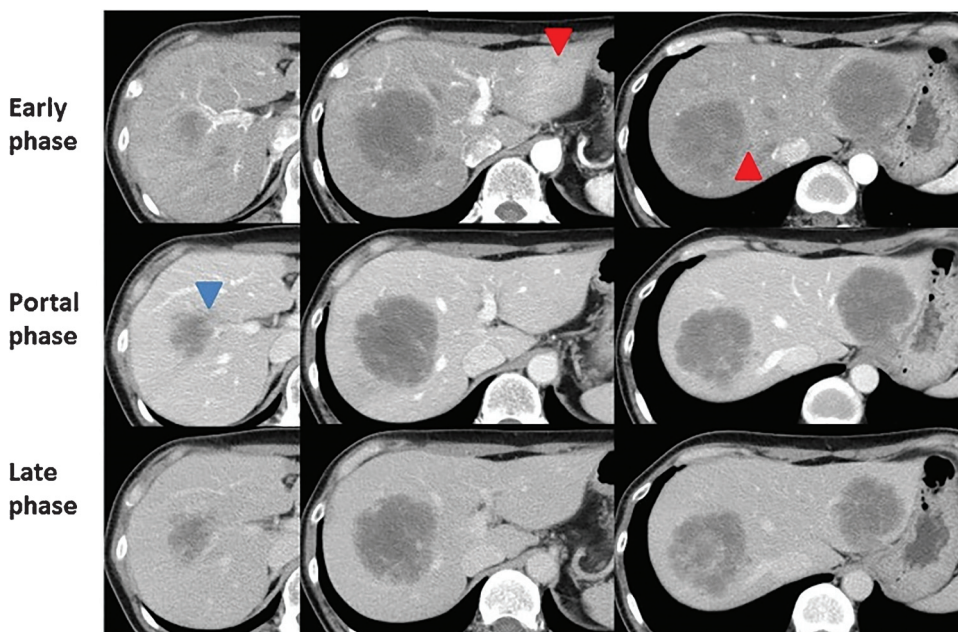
CT images at admission. Computed tomography (CT) showed two low-density masses of 68 mm in diameter in hepatic segments 2 and 3 and 72 mm in diameter in segment 8 as the main loci. These tumors were diagnosed as intrahepatic cholangiocarcinoma and were suspected to invade the right Glisson's sheath (blue triangle) with multiple intrahepatic metastases (red triangles).
